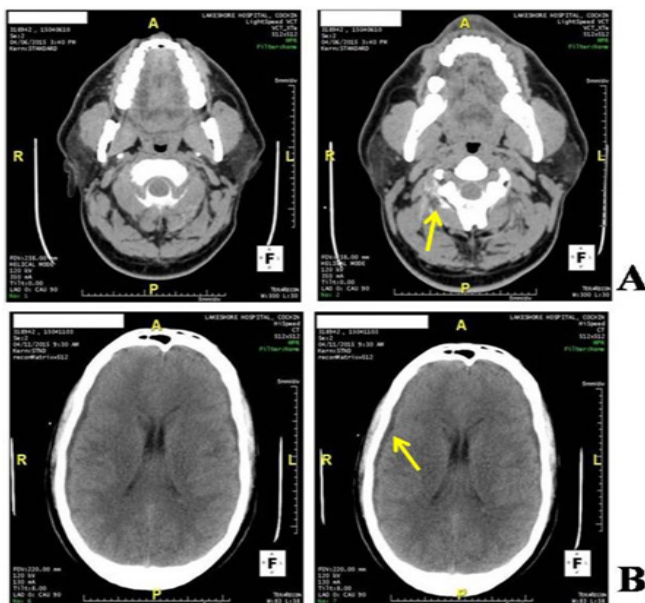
CT. (A) Myelography showing extradural contrast extravasation at C2-C3 level (as marked by the arrow); (B) plain CT brain after epidural blood patch showing mild reduction in the extent of subdural effusions (as marked by the arrow)
